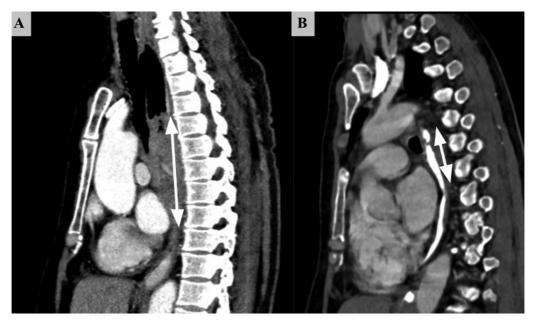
Post-neoadjuvant chemoradiotherapy (NACRT) response assessment with computed tomography (CT). Contrast-enhanced CT (CECT) thorax in sagittal view showing esophageal tumor in the middle and lower thoracic esophagus. Post-NACRT, there is decrease in the longitudinal tumor extent.
